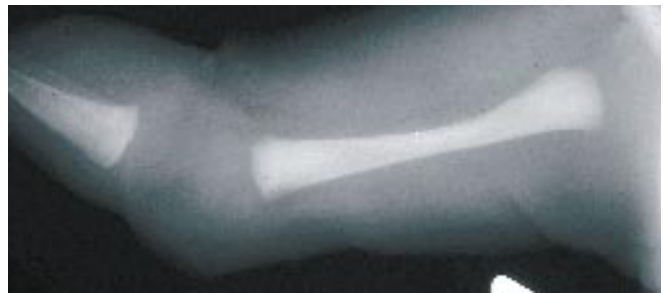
Looking for epiphyseal centers in long bone radiographs is useful in the assessment of gestational age. The lower extremity radiographs show the proximal tibial epiphyseal center, which generally appears by 36 weeks gestation, being followed by the distal femoral epiphyseal center at 38 weeks gestation. In this patient no epiphyseal centers are seen, consistent with the infant's gestational age of 35 weeks. Conditions that may alter the normal appearance of the centers include hypothyroidism, congenital viral infections, and congenital syphilis.
